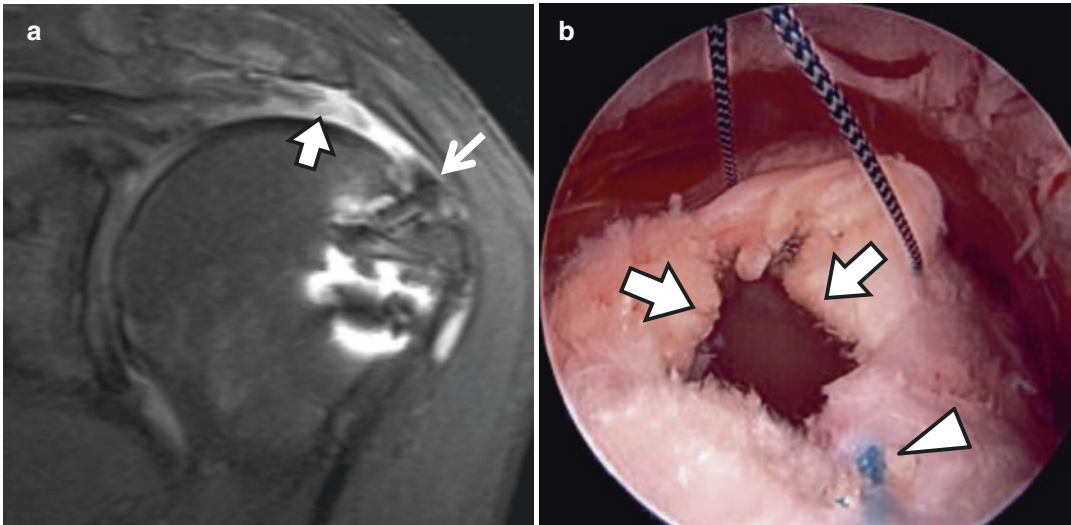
65-Year-old woman status post-rotator cuff repair 4 months prior with worsening shoulder pain and characteristic failure location after double-row repair. (a) Coronal oblique intermediate-weighted fat-suppressed MR image shows a full-thickness retear of the distal supraspinatus tendon with retraction (thick arrow). Small
